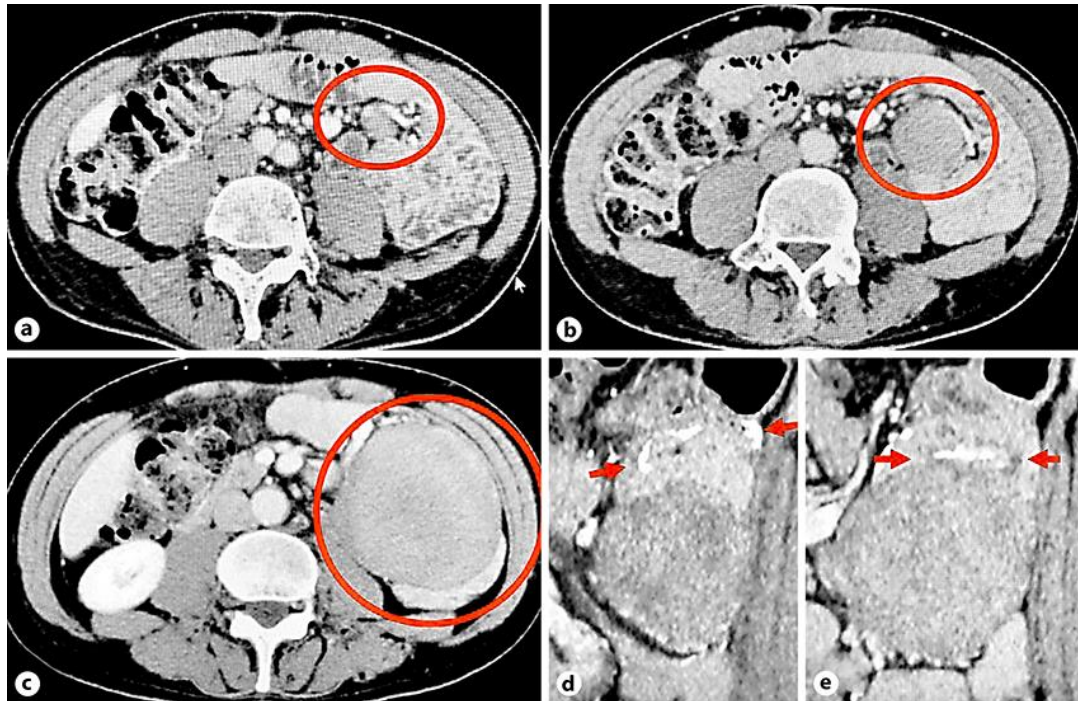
Computed tomography (CT) images. a A new, 14-mm mass appeared adjacent to the Roux-en-Y limb without invasion into the small bowel (22 months ago; circle: tumor). b The tumor increased in size to 33 mm 6 months ago (circle: tumor). c–e Preoperative CT showed a heterogeneously enhanced tumor with a diameter of 82 × 75 mm by axial (c) and coronal imaging (d, e) (arrows: anastomotic site; circle: tumor).
